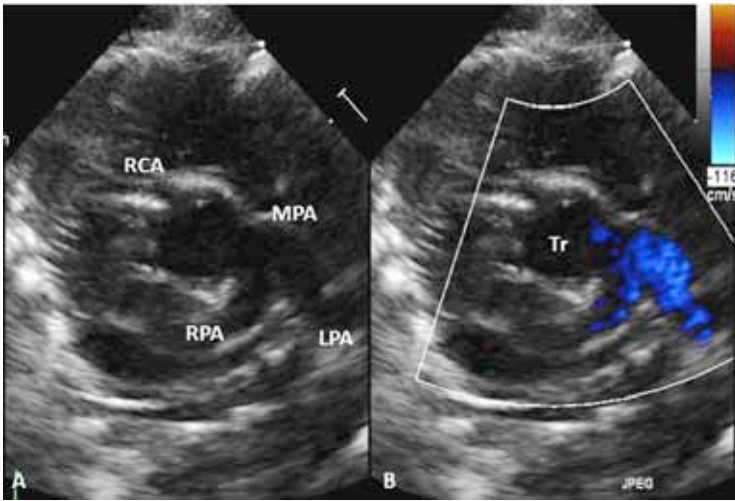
Parasternal short-axis views in 2D (A) and color Doppler (B) showing origin of main pulmonary artery from the truncus (Tr). The main pulmonary artery (MPA) is short and bifurcates into right (RPA) and left (LPA) pulmonary arteries. In B, color Doppler imaging shows non-turbulent flow in both pulmonary arteries. RCA, right coronary artery.
